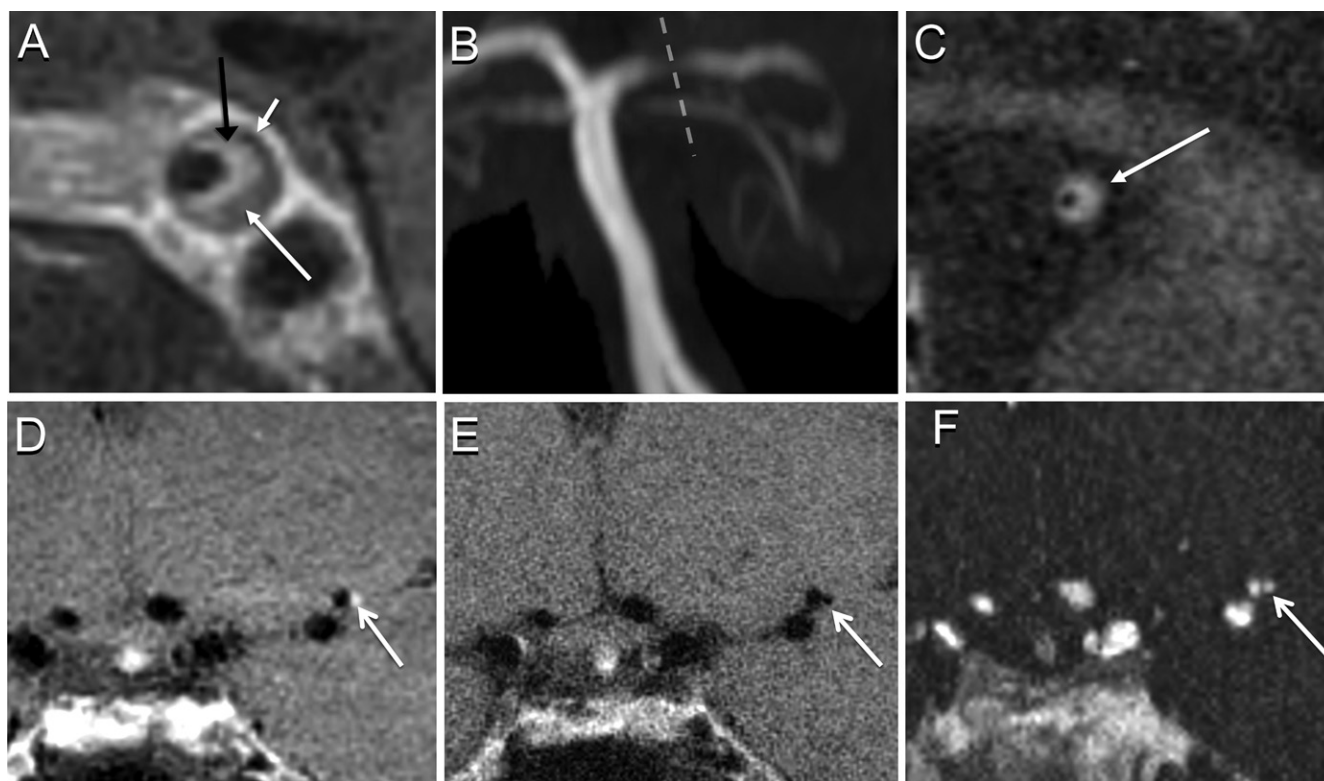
Resolution constraints in characterizing intracranial vessels. (A) Three-dimensional (3D) vessel wall (VW) MRI scan of a cavernous segment of a left internal carotid artery (ICA) shows characteristic features of an atherosclerotic plaque with a contrast-enhancing fibrous cap (black arrow), hypoenhancing lipid core (long white arrow), and small focus of hypointense calcification (short white arrow). (B, C) For comparison, VW MRI of a P1 segment of the left posterior cerebral artery as prescribed on a time-of-flight MR angiography (line in B) in a different patient shows an enhancing eccentric atherosclerotic plaque (C). Both plaques were imaged using an acquired resolution of 0.5 mm^3 , but the internal components of the posterior cerebral artery plaque are too small to characterize (maximum thickness, $\leq 1 \text{ mm}$) in contrast to the large cavernous plaque (maximum thickness, approximately 3 mm). (D) In a 52-year-old woman with clinical concern for intracranial vasculitis, focal enhancement along the lateral wall of the M2 segment of the left middle cerebral artery on a coronal postcontrast VW MRI scan cannot be distinguished from the arterial wall, raising suspicion for plaque (arrow; acquired resolution, 0.5 mm^3). (E, F) A two-dimensional black-blood MRI scan (E) acquired in the same patient and at the same location as D shows a patent lumen of a small vein near the M2 segment (arrow, $0.35 \times 0.35 \times 2 \text{ mm}$), also seen on the venous phase contrast-enhanced MR angiographic image (F).
